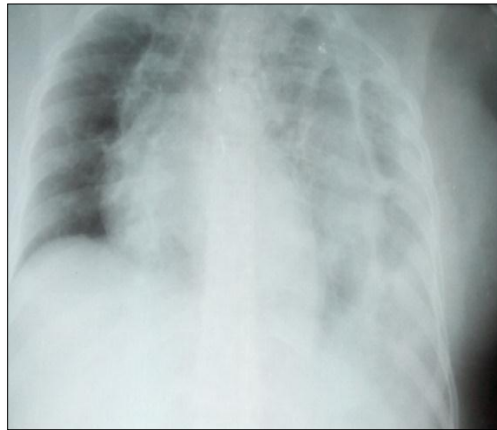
Chest X-ray showing a disappearance of the left diaphragmatic dome.
